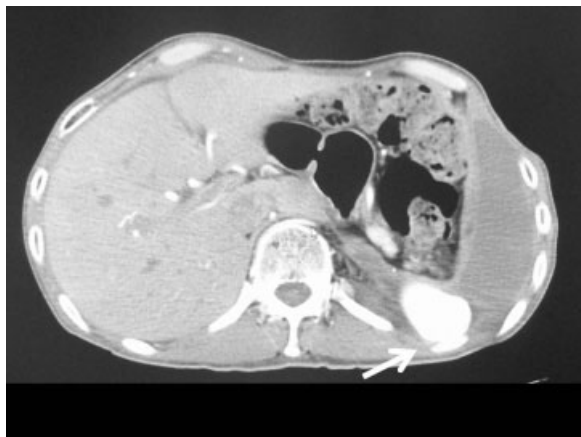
A postoperative computed tomographic scan after thoracic endovascular aortic repair showing that the graft was closely positioned in contact with the rib (arrow).
